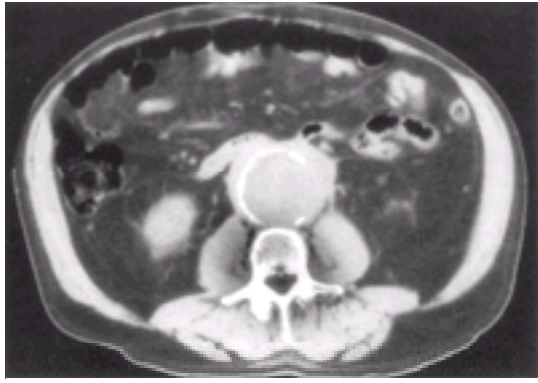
CT scan of an inflammatory abdominal aortic aneurysm, showing the thick aortic wall.
